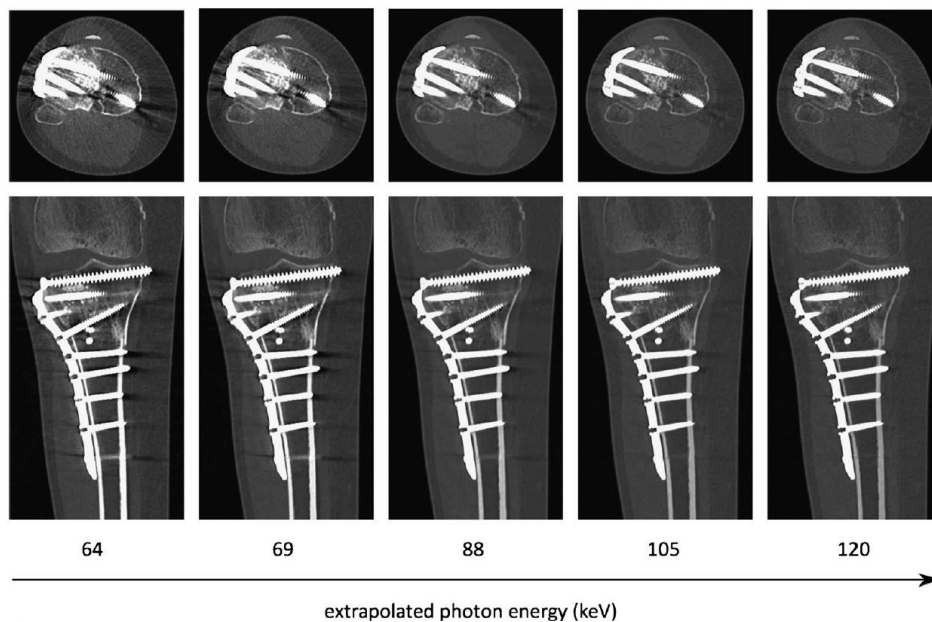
Metal artifacts decrease as photon energy increases in single energy extrapolated images from dual-energy CT. Reprinted from Meinel *et al.* [32] with permission from Wolters Kluwer.
